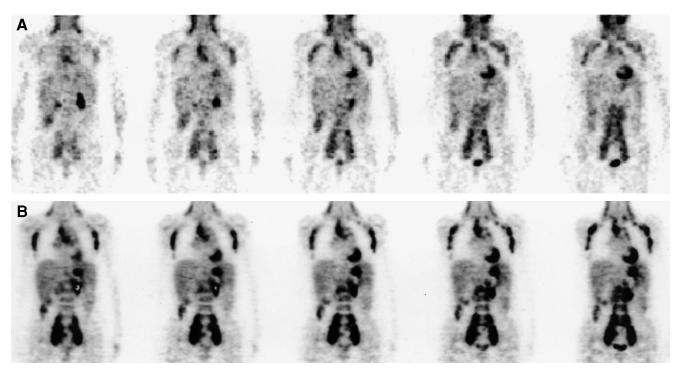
Patient 10. Coronal images obtained by FDG hybrid PET (A) and dedicated PET (B). Bilateral cervical to axillary, mediastinal, and para-aortic to bilateral iliac sites are detected on both sets of images. Clearer images and higher lesion-to-background contrast are achieved with dedicated PET than with hybrid PET.
